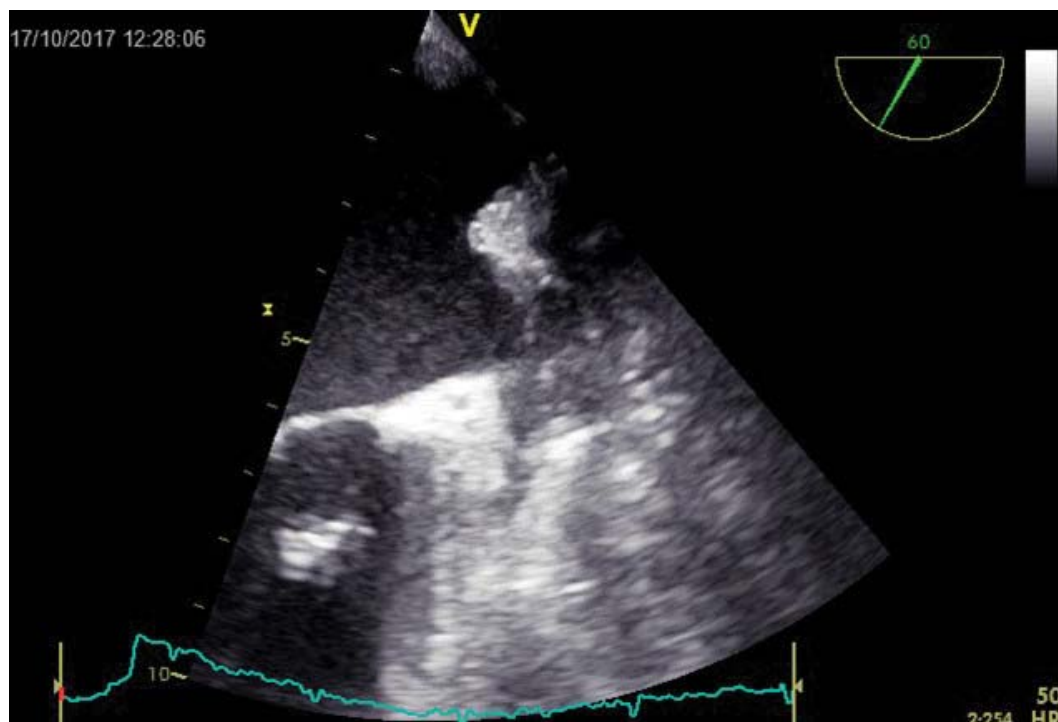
Transoesophageal echocardiography image showing left atrial appendage thrombosis.
